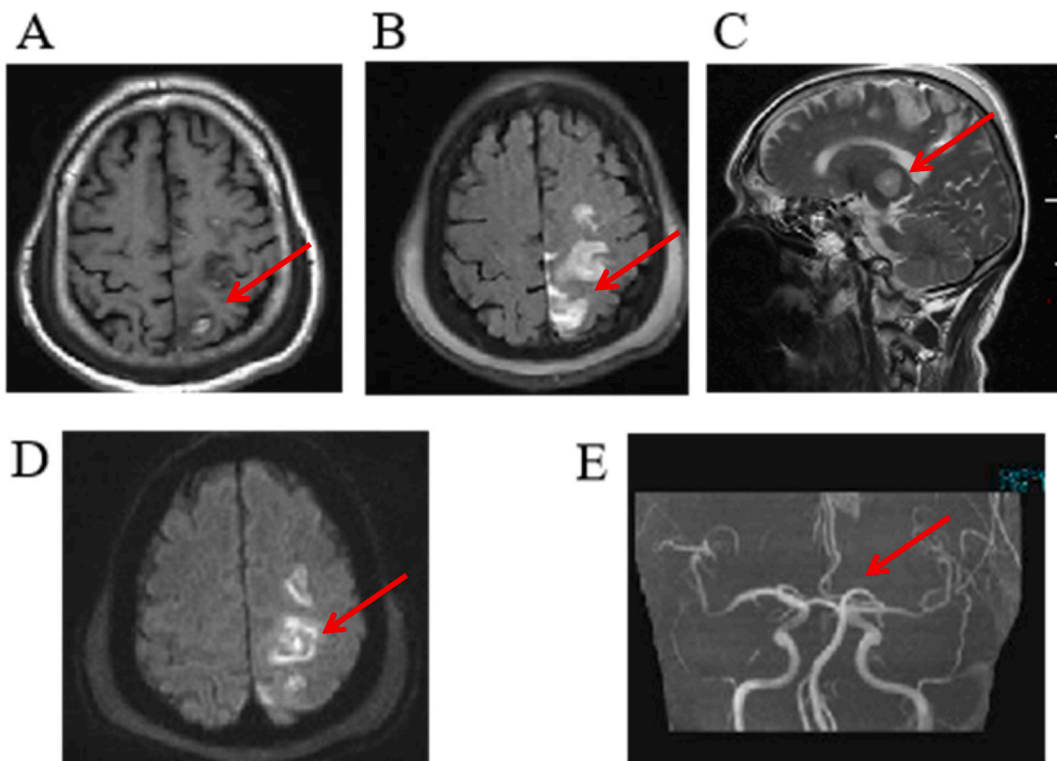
Magnetic resonance imaging showed huge swelling in the head.
